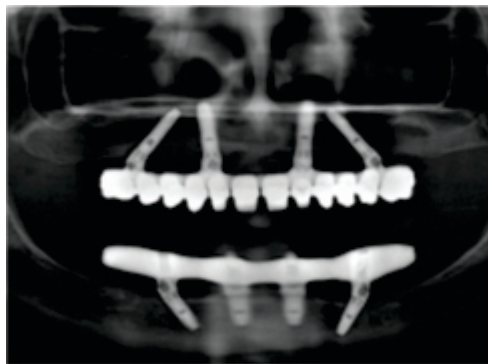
36 All on four implant prosthesis radiographic image
